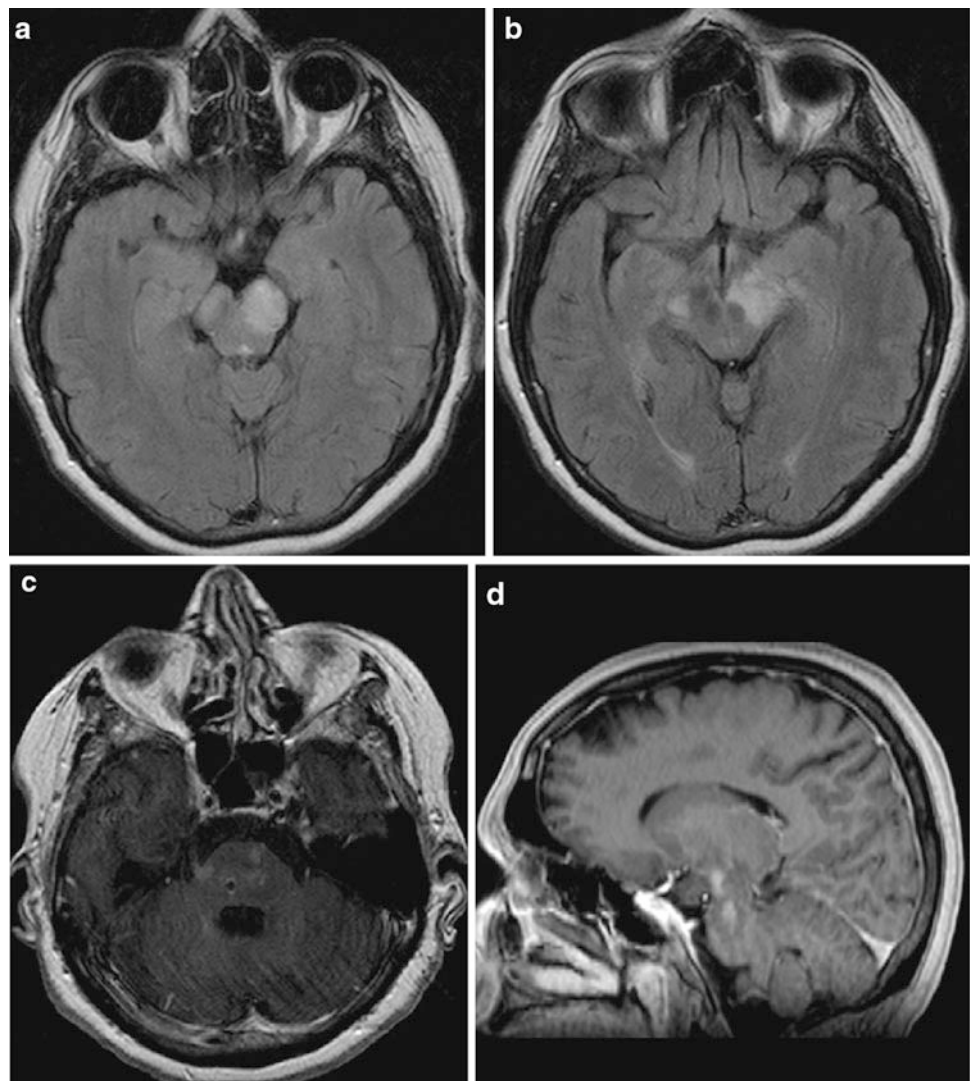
A 20-year-old woman with Sjögren syndrome and associated CNS vasculitis. Since the age of 16 she has been suffering from sicca symptoms and hypothalamic dysfunction, the latter resulting in narcolepsy as well as postural and gait instability. a Axial FLAIR image. b Axial DWI. c Coronal T1-weighted MR image after contrast administration. Bilateral hyperintensities of the basal ganglia, predominantly of the left
